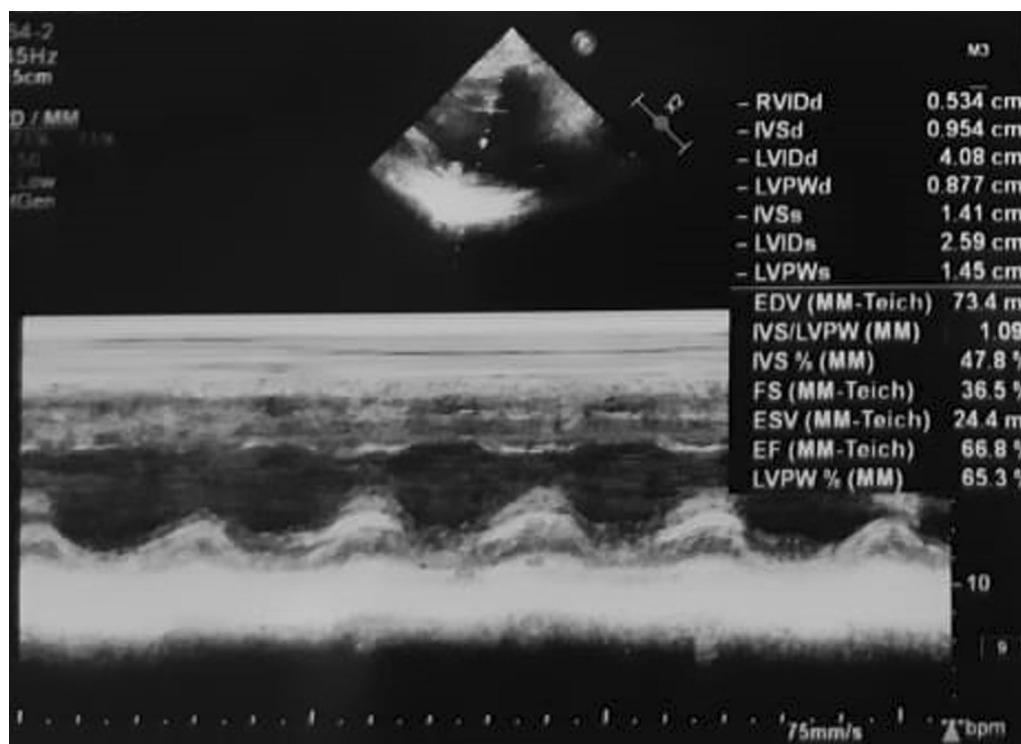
Echocardiograph before outpatient showed no hypokinetic with normal EF (66.8%)
